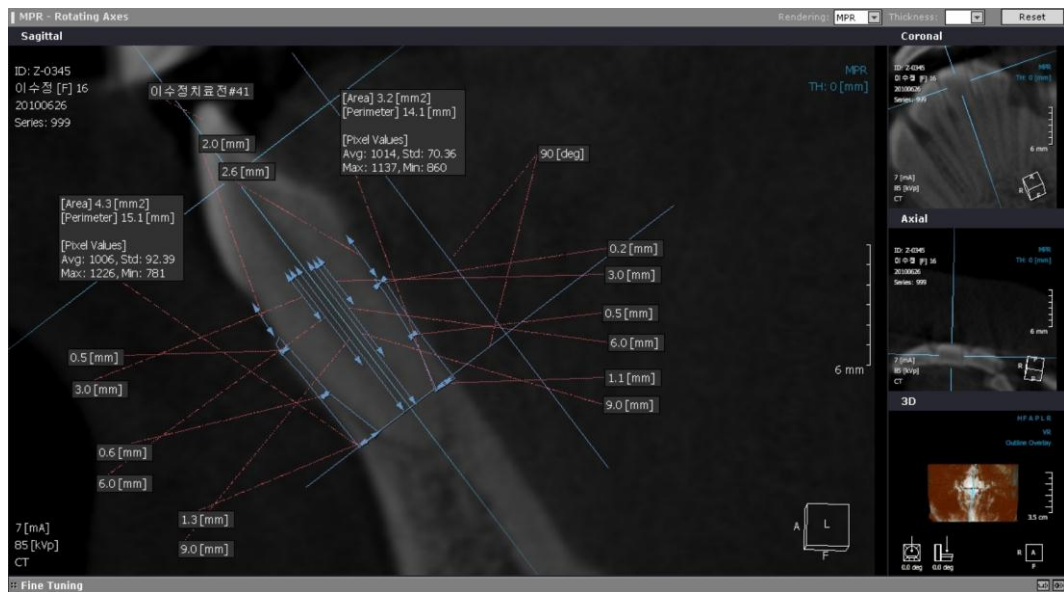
CBCT analysis of #41 before Treatment ( T1 )
